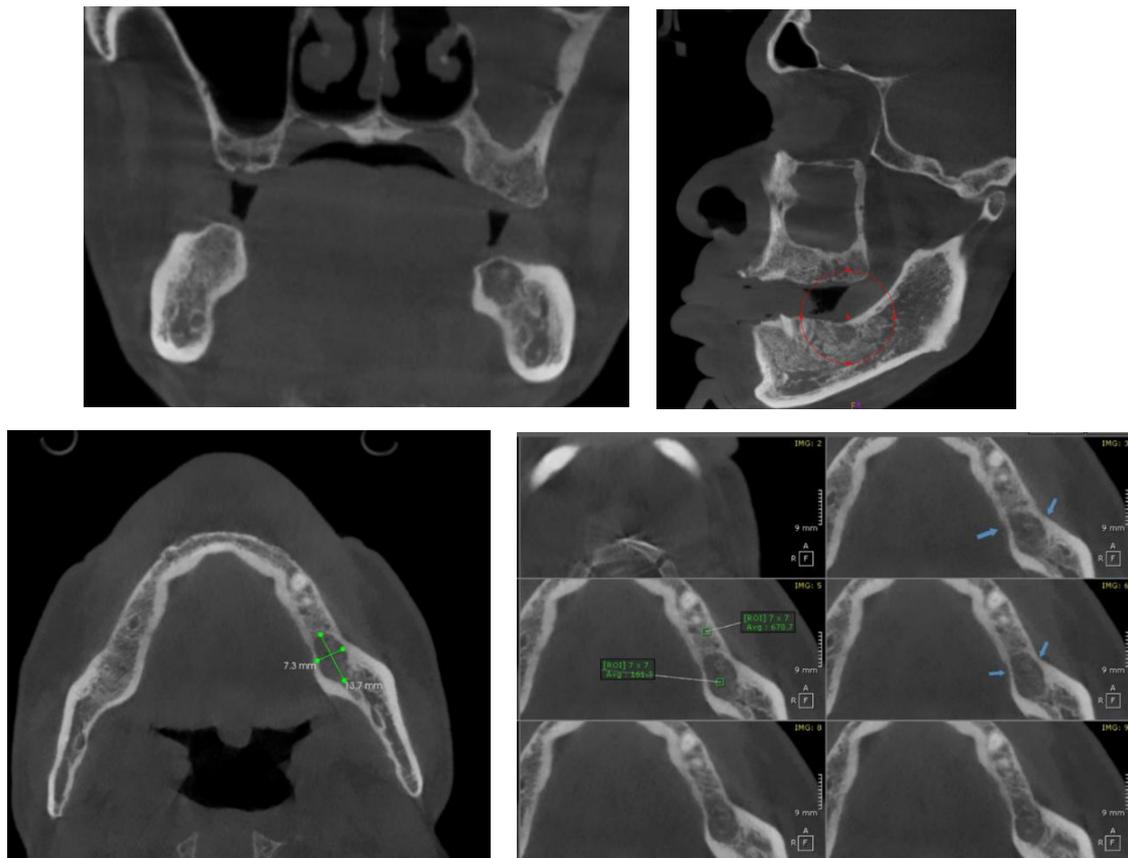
CBCT examination (Coronal, Sagittal and Axial view) shows a radiolucent area in the left posterior mandible with well-defined, with corticated borders, cortical thinning is observed of the lingual cortical plate with a slight cortical defect, unilocular defect with no associated cortical expansion (personal archive).
